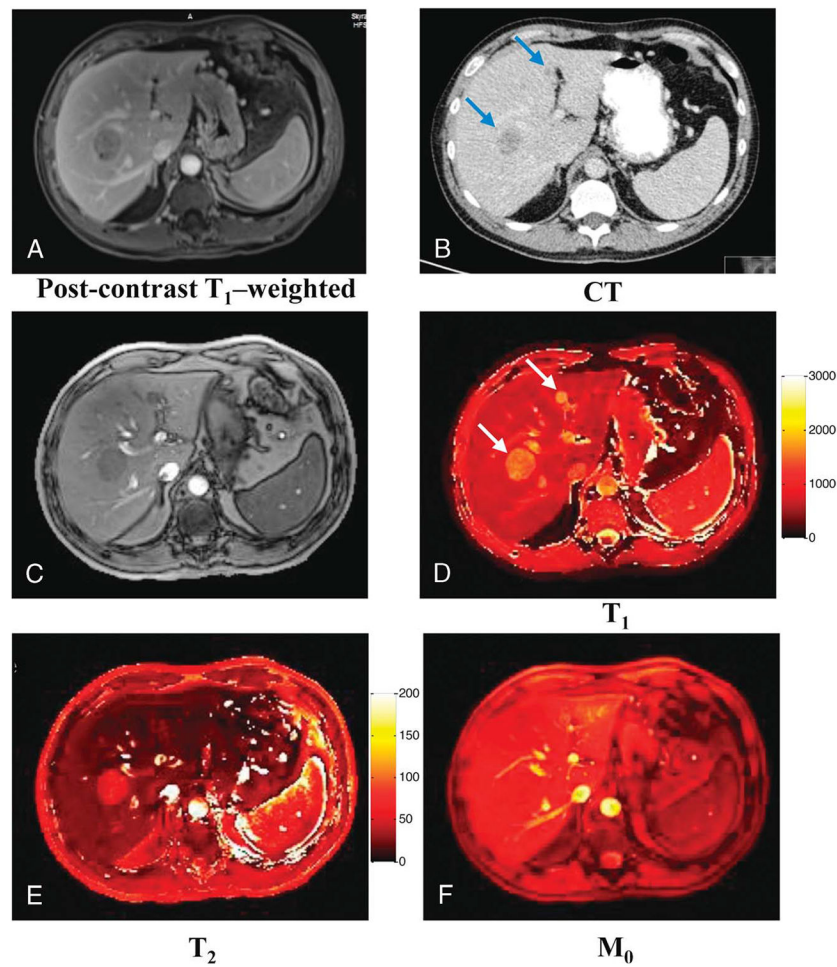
Quantitative maps acquired from a patient with metastatic lung adenocarcinoma. A, Conventional postcontrast T₁-weighted image. B, CT image. C, Image summed up from all undersampled images. D–F, Quantitative T₁, T₂, and M₀ maps. Two metastatic lesions with sizes of 32.9 and 9.8 mm were observed from both conventional images and quantitative maps. Figure originally printed in Chen et al.¹¹⁶
